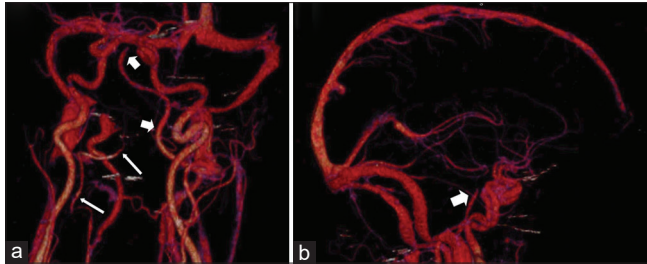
(a) CT angiogram head and neck 3D reconstruction, anterolateral view. Right vertebral artery ends in right PICA (thin arrows). Left vertebral artery is sole supply of basilar artery. Distal basilar artery occlusion is demonstrated. (thick arrows). (b) Lateral view. Distal basilar artery occlusion visualized (thick arrow). CT: Computed tomography, 3D: Three dimensional, PICA: Posterior inferior cerebellar artery
